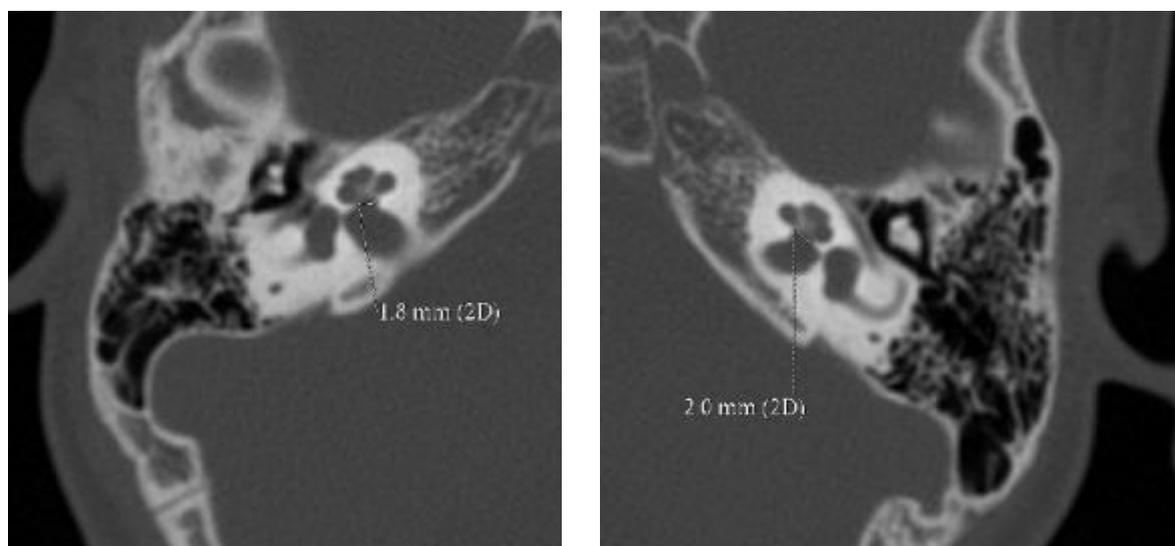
a. Normal bony canal for the cochlear nerve in a 6-year-old boy who underwent a temporal bone examination for SNHL. Transverse, thin-section CT scan through the midportion of the modiolus shows a
